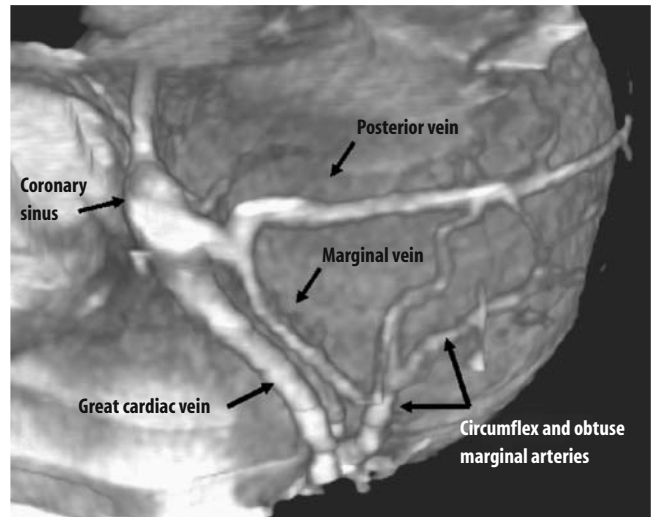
CT angiography image demonstrating a coronary branch vein, which subsequently bifurcates into a posterior and marginal branch. The circumflex and obtuse marginal branch arteries are also visualized.
